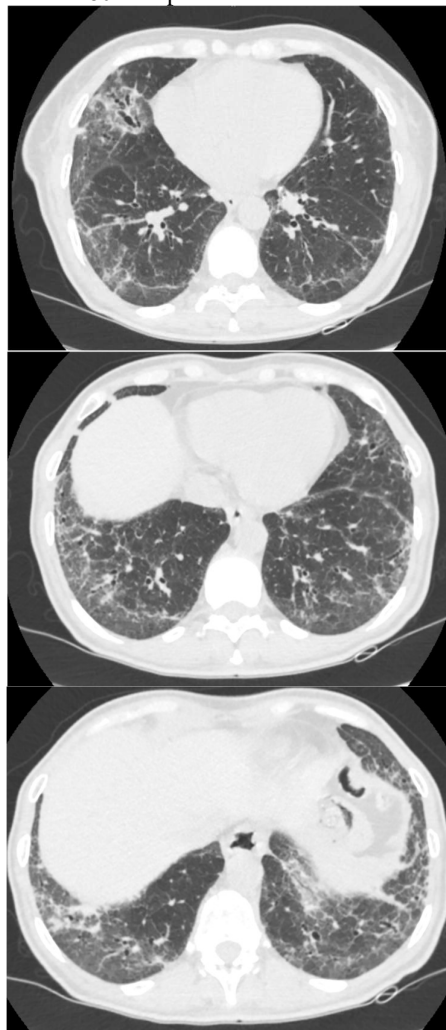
CT images showing nonspecific interstitial pneumonia pattern.
